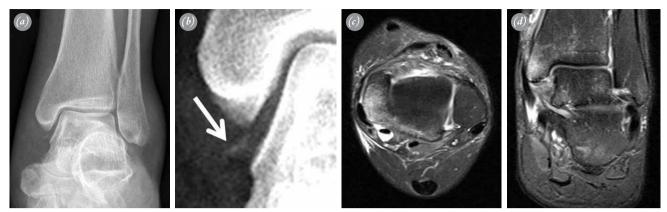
Plain radiograph 6 weeks after initial injury showed a small avulsed fragment under the tip of (a) the left medial malleolus, which was highlighted on (b) the right inset. (c) T2 axial and (d) coronal MRI revealed anteriorly dislocated posterior tibial tendon with detached flexor retinaculum.
